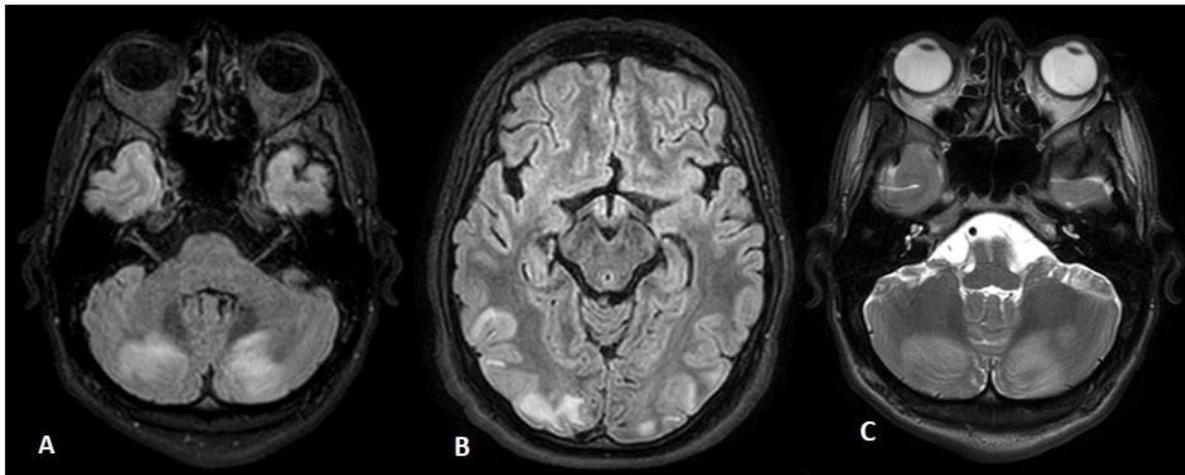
Brain MRI in a 24-year-old man with stage III germinal testis tumors, who developed photophobia and confusion after the first course of chemotherapy, showing bilateral and symmetrical fluid-attenuated inversion recovery (A, B) and T2 (C) hyperintensities in the posterior white matter consistent with posterior reversible encephalopathy syndrome.
